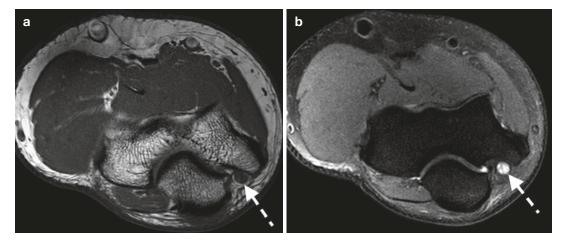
MRI of ulnar neuropathy within the cubital tunnel: (a) axial T1 and (b) axial T2FS demonstrating enlarged ulnar nerve (*dashed arrow*) with increased signal intensity on T2. Compare to Fig. 3.31 for normal appearance
